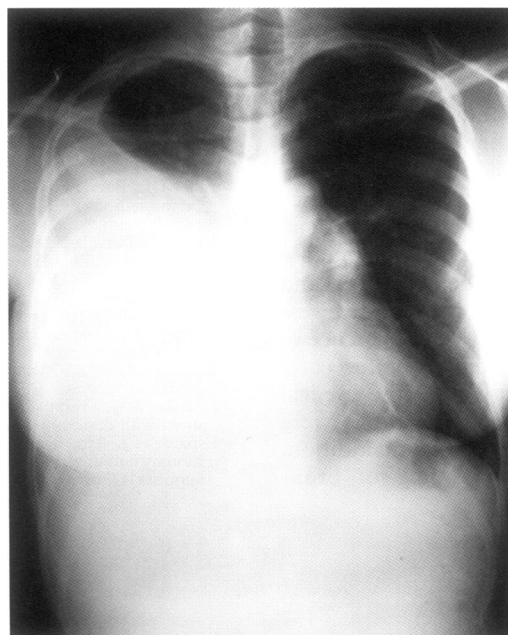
Chest radiograph at presentation.
